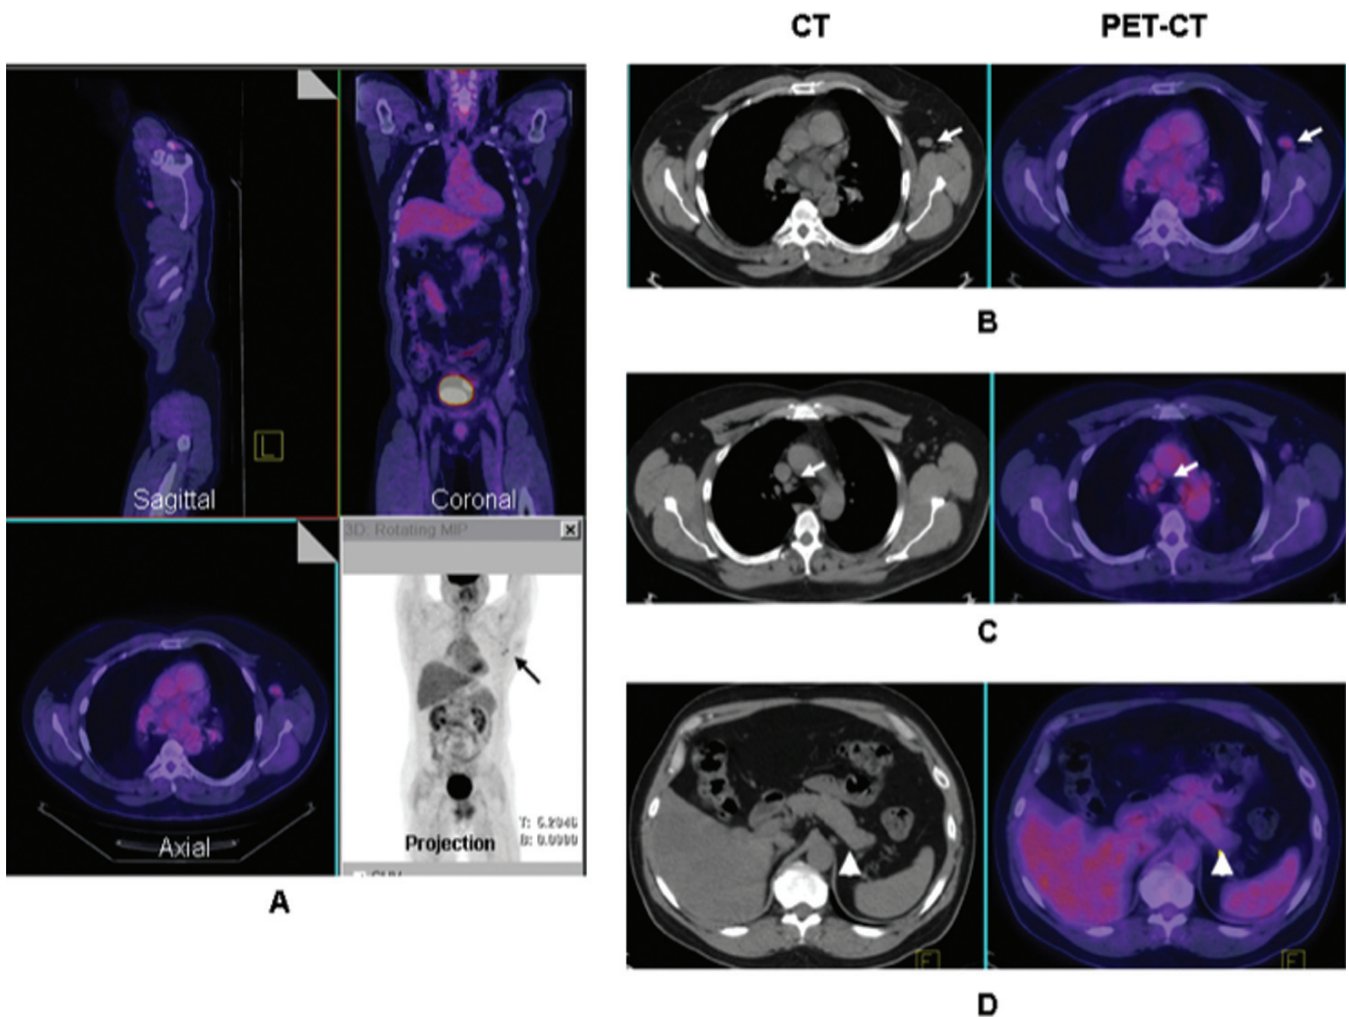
PET/CT 3D fusion and projection images showing enlarged left axillary lymph nodes (black arrow) in A; Axial and fused PET/CT images showing enlarged left axillary lymph nodes in B; mediastinal lymphadenopathy in C; and diffuse pancreatic swelling in D.
